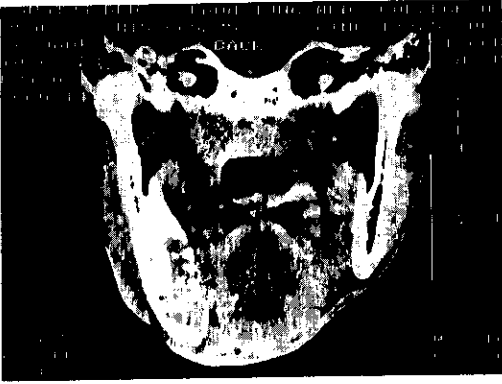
CT scan showing an expansile osteolytic lesion of the right mandibular body (arrowheads).
